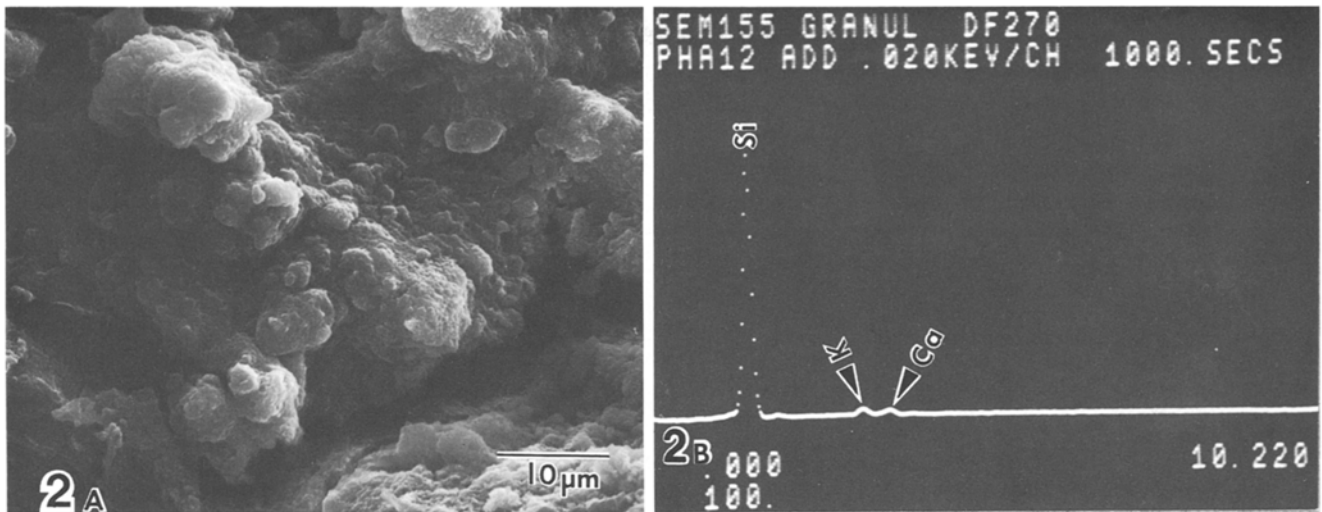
Deposition of granular particles with mammillary tuberosities in a uric acid stone (a). X-ray analysis of the deposit yielded silicon and trace amounts of potassium and calcium (b)
